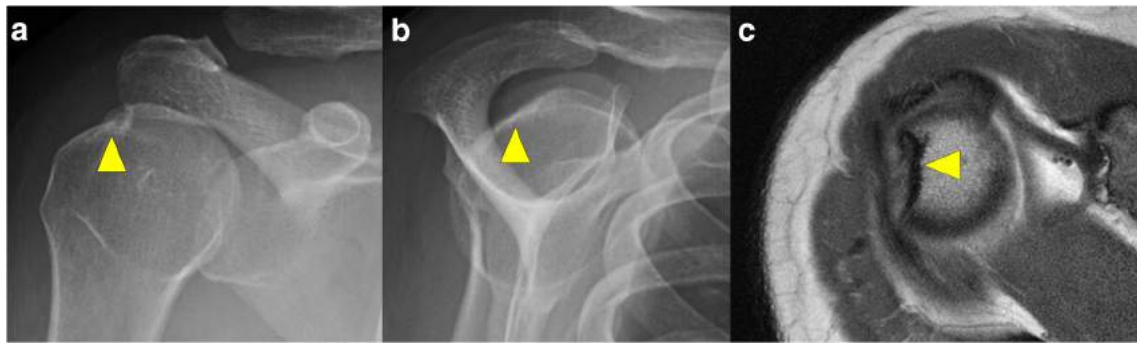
Hill-Sachs lesion (arrowhead) by radiographic AP internal rotation (a) and scapular Y views (b) and MRI axial proton density (c)
